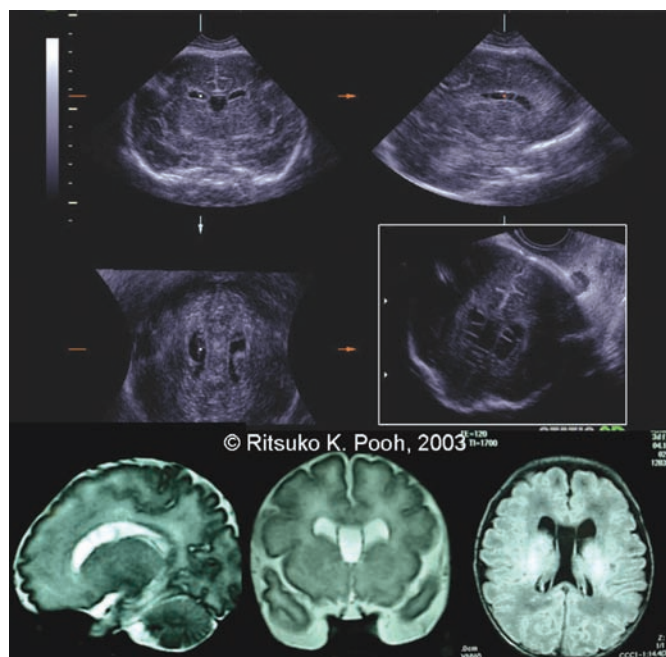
Subependymal cysts (fetal ultrasound images and neonatal MR images). (Upper) Coronal and sagittal images. (Middle left) Axial image. (Middle right) Anterior coronal section. Note bilateral bead-like cystic formation. (Lower) MR sagittal, coronal, and axial images at 3 days after birth. No neurological symptoms at the age of 1 year.
